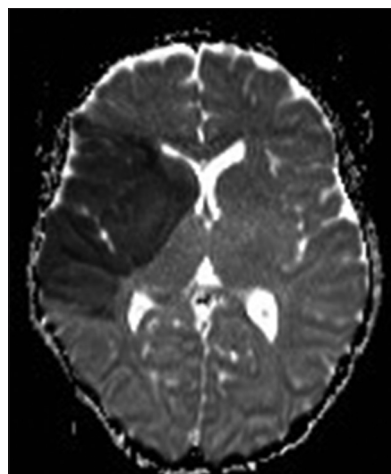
Magnetic resonance imaging (apparent diffusion coefficient scan) of the same patient
